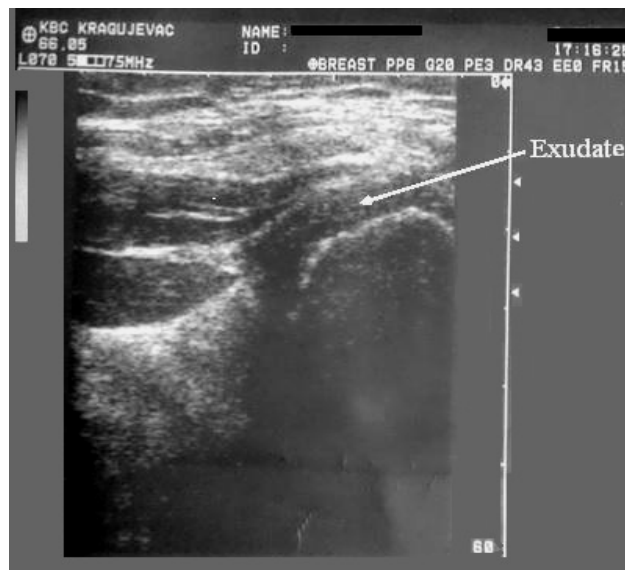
Ultrasonography of the affected joint
